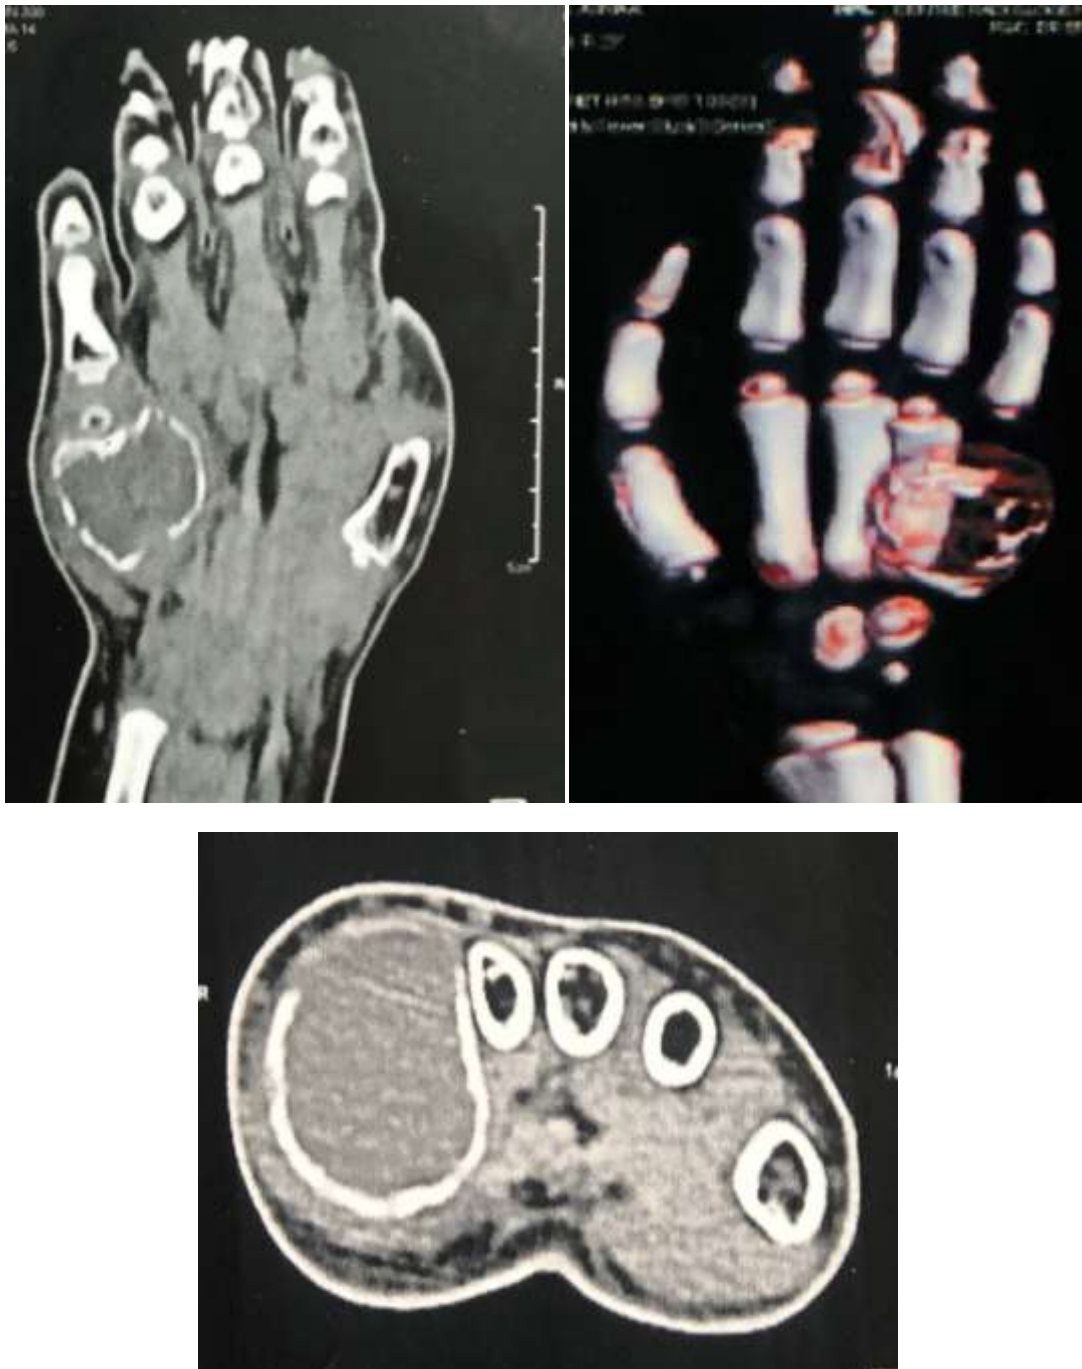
CT-scan: osteolytic expansile mass of the 5th metacarpal bone without invasion of the soft parts and without cartilaginous matrix.
